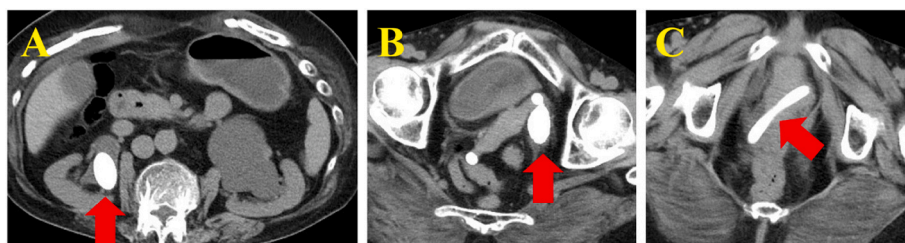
Preoperative CT shows: A) a right renal stone (arrow) and left hydronephrosis; B) a left ureteral stone (arrow); and C) a ring pessary (arrow).
